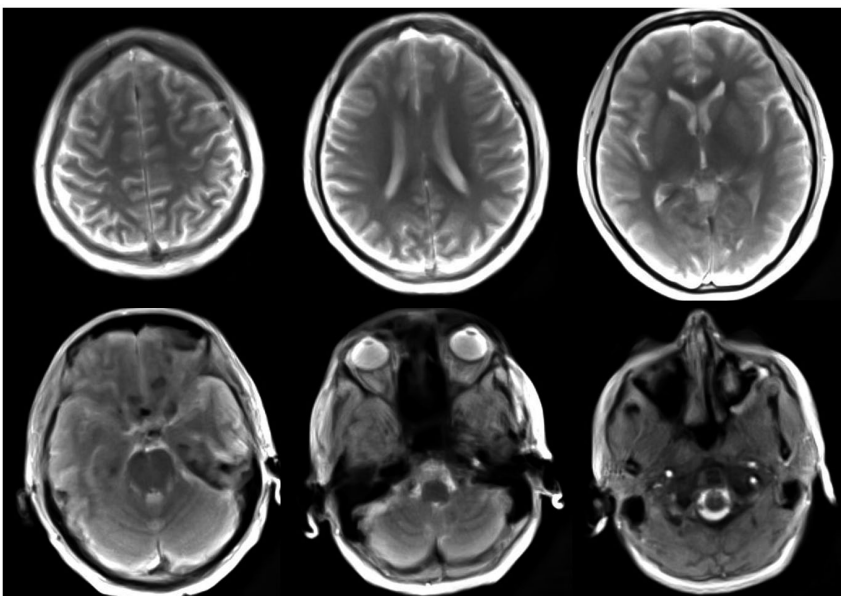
Selected T_2/T_1 -weighted images (every 15th) of a 5.0-second real-time MRI acquisition covering the brain (150-mm volume) of a healthy subject at 50.0 ms and $1.0 \times 1.0 \times 6.0 \text{ mm}^3$ resolution. For details, see Table 1
